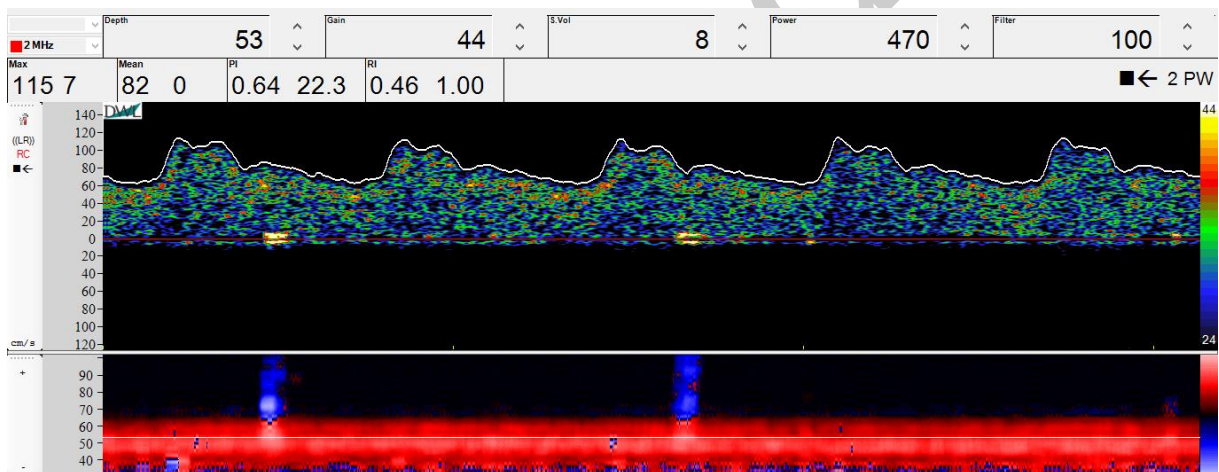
An example of transcranial doppler ultrasound in the target vessel after water pipe smoking (flow analysis in right MCA)
